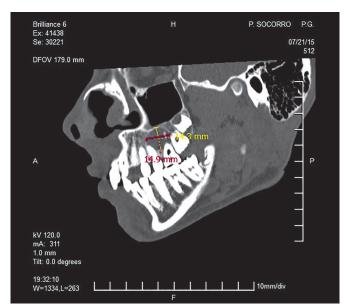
Sagittal cone-beam computed tomography.
